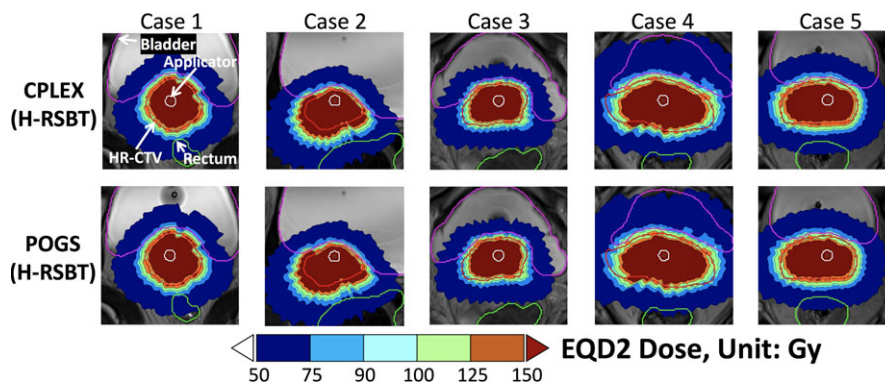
EQD2 dose distributions on MR images for five patient cases obtained from CPLEX and POGS with H-RSBT using 45° azimuthal angle. [Color figure can be viewed at wileyonlinelibrary.com]
